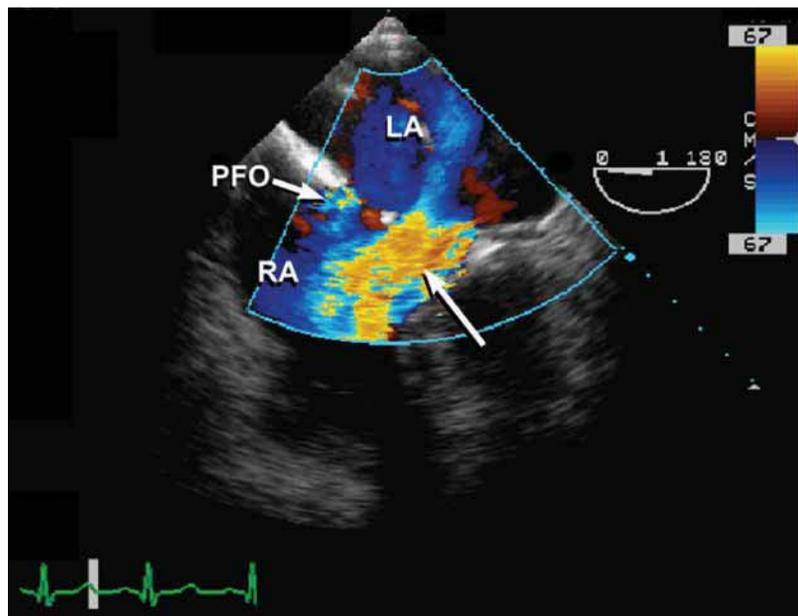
Color flow Doppler demonstrates the presence of the coronary sinus ASD with left-to-right shunt. Note also the small shunt arising from a patent foramen ovale (PFO).
